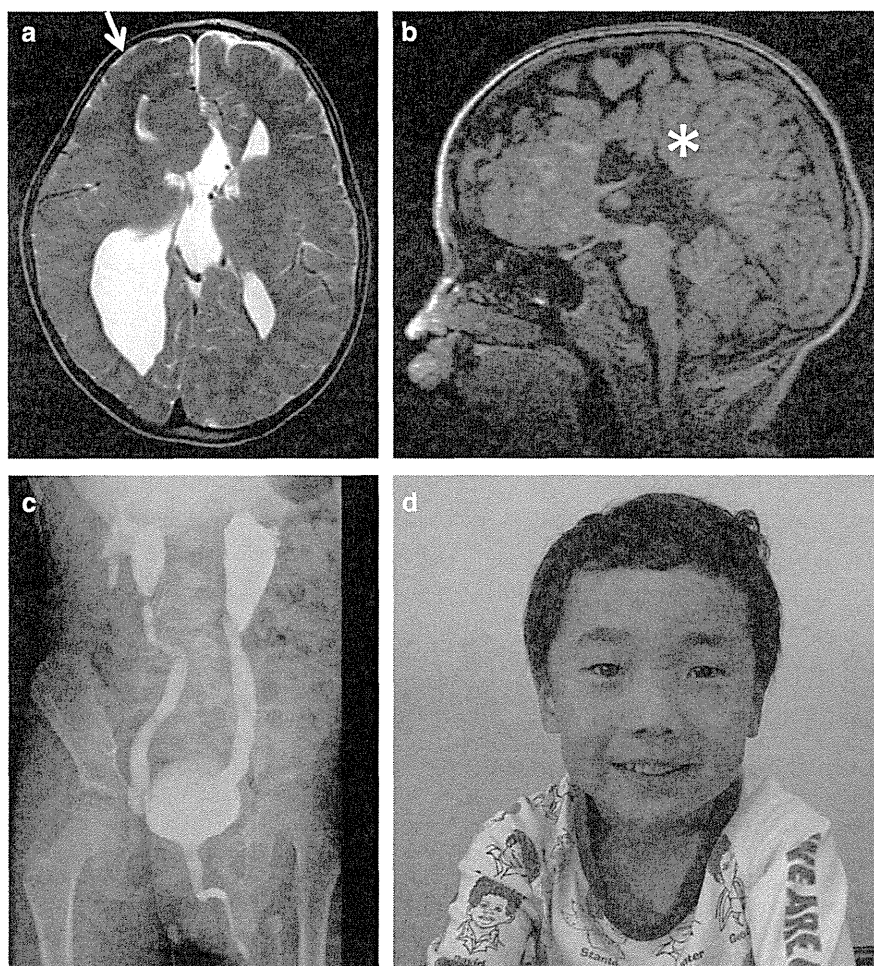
Head MRI, voiding cysturethrogram (VCUG) and craniofacial appearance of our patient. (a) Axial T2-weighted image showing interhemispheric cysts, ventricular enlargement and polymicrogyria (arrow). (b) Mid-sagittal T1-weighted image showing callosal agenesis (asterisk). (c) The VCUG showed bilateral grade IV vesicoureteral reflux. (d) Representative photograph of the patient showing a little dysmorphic facial features including mild macrocephaly, high forehead, and thin upper lip. His parents gave informed consent for publication of this image.
